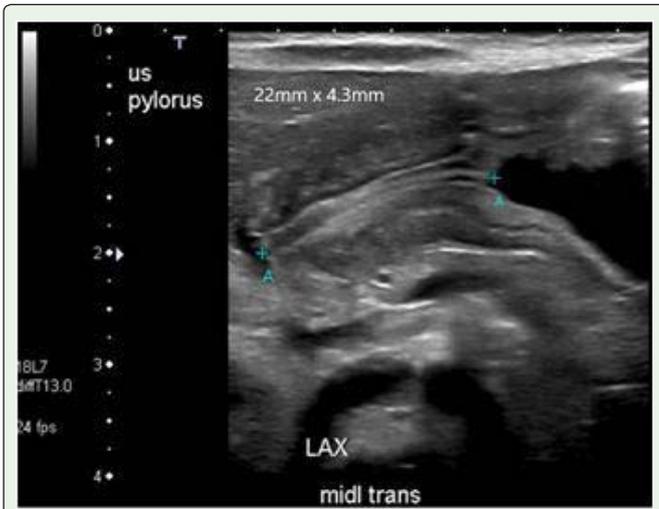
The initial ultrasound showed hypertrophic pyloric stenosis. The pyloric channel had a length of 25 mm and a thickness of 4.3 mm.
